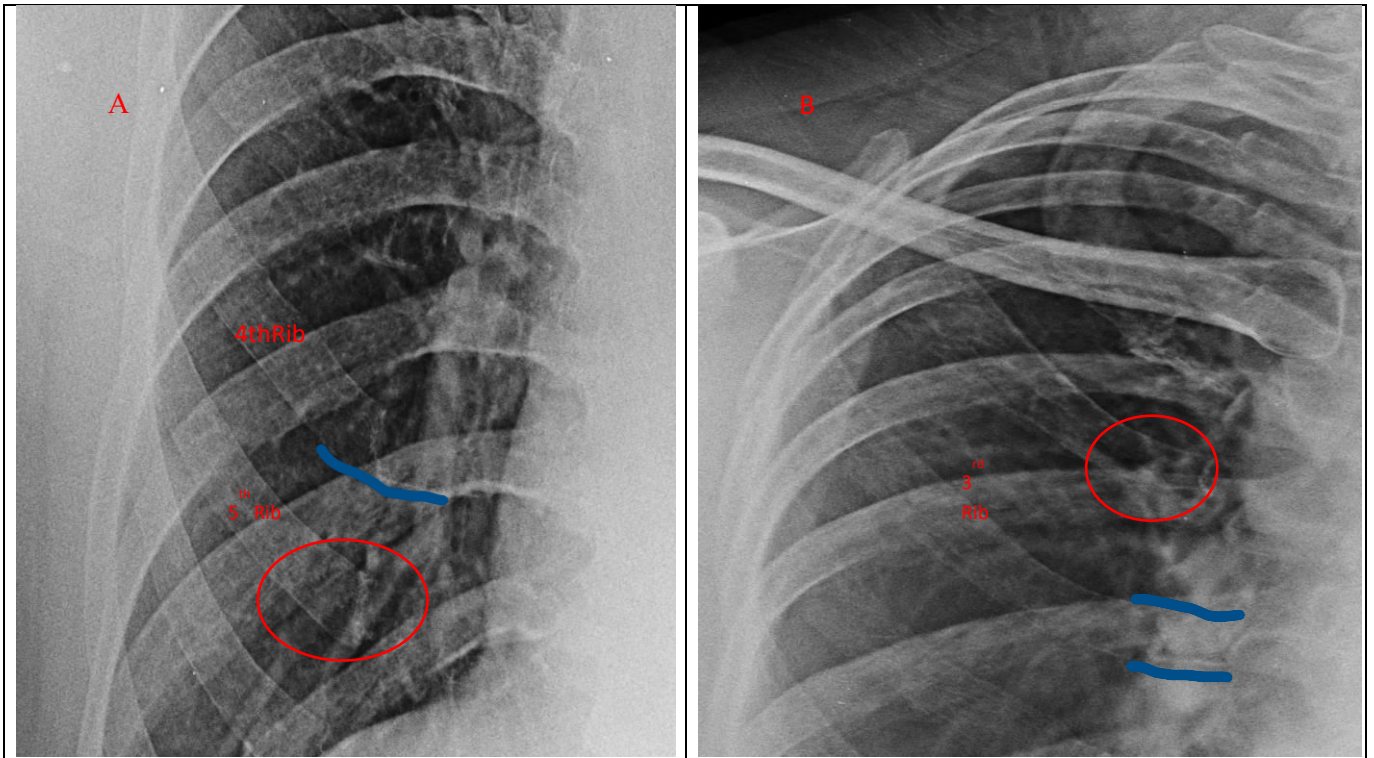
Mixed CCC on a male radiograph (A) and a female radiograph (B).
